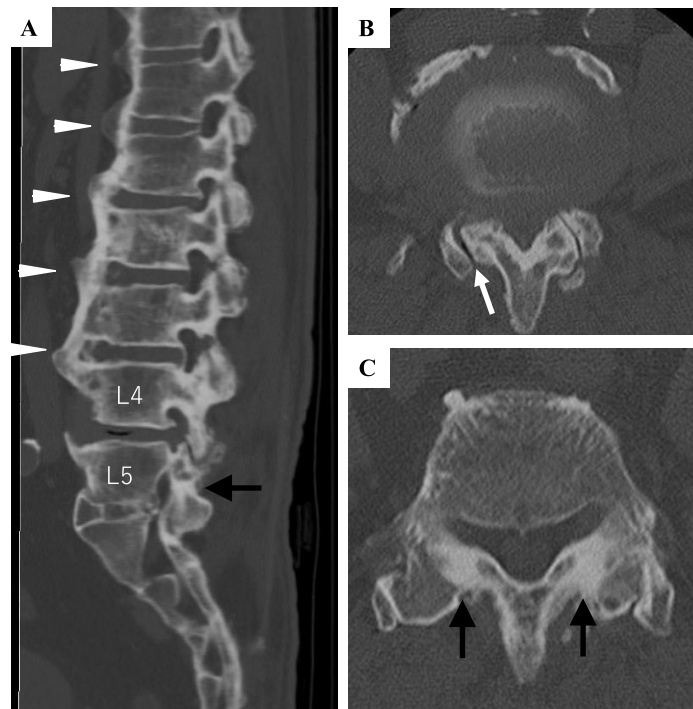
Computed tomography (CT) of the lumbar spine (A: sagittal view, B: L4-5 axial view, C: axial view of L5-S). Sagittal view shows ossification of anterior longitudinal ligament at Th11-L4 (A: white arrowheads). Synostosis at L5-S1 was completed (A, C: black arrows). Vacuum at intervertebral joint of L4-L5 appeared (B: white arrow). These findings mean that movement was focused in only the L4-L5 intervertebral space.
